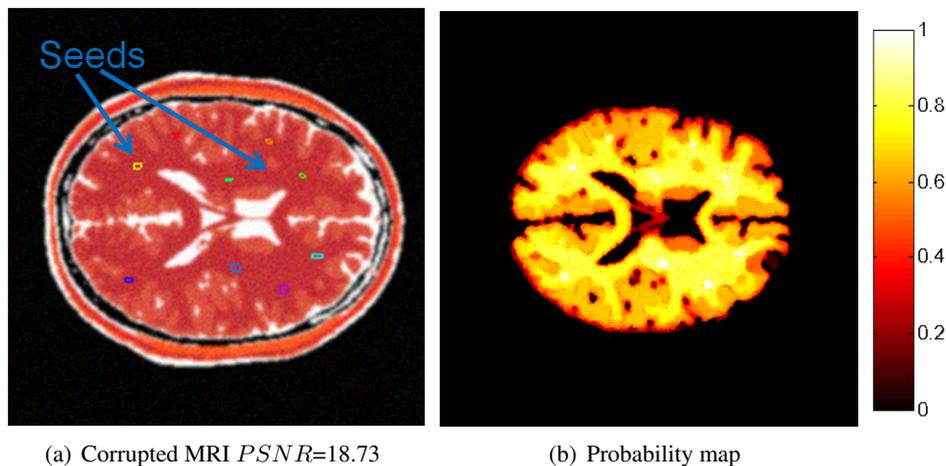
Probability map of white matter segmentation of corrupted MRI image by using MS and RG.
